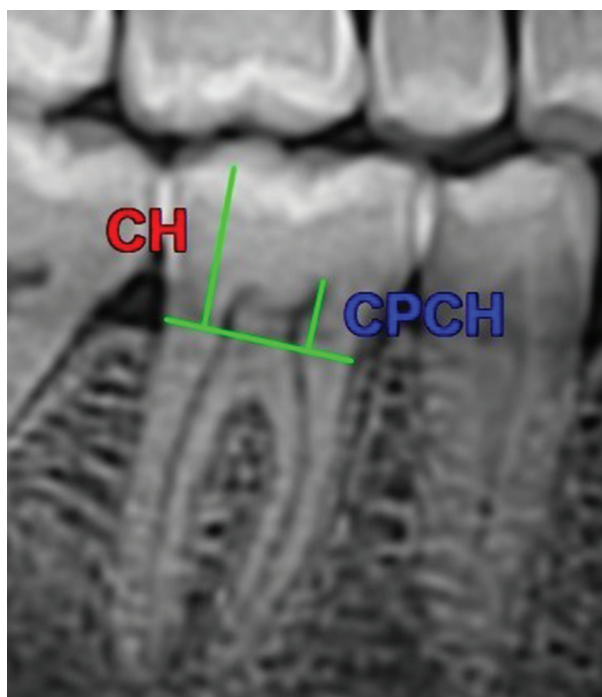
Left mandibular first molar measurements to calculate tooth coronal index on panoramic radiography. Coronal height (CH) was measured from the cemento-enamel junction (red line) to the tip of the cusp. Coronal pulp cavity height (CPCH) was measured from the cemento-enamel junction to the tip of the pulp horn.
